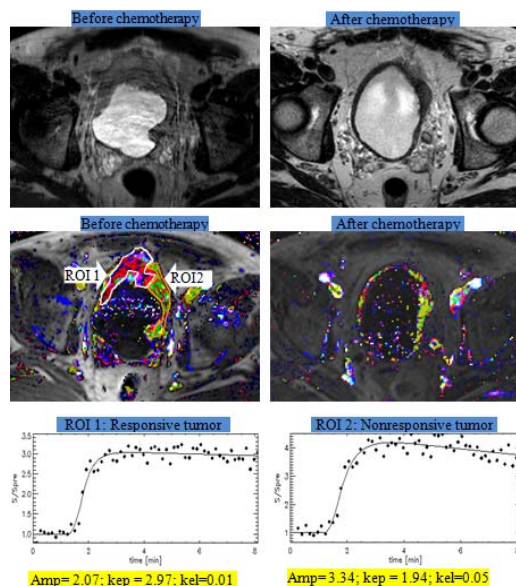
(a male patient, age = 59): Row 1: The responsive and non-responsive ROIs were isointense on the T2w-MRI images; Row 2: Color Amp+kep maps were able to display the two ROIs; Row 3: Signal enhancement curves showed the difference in perfusion characteristics of the responsive tumor ROI (lower Amp and k_{el} , higher k_{ep}) and the non-responsive tumor ROI (higher Amp and k_{el} , lower k_{ep}).
